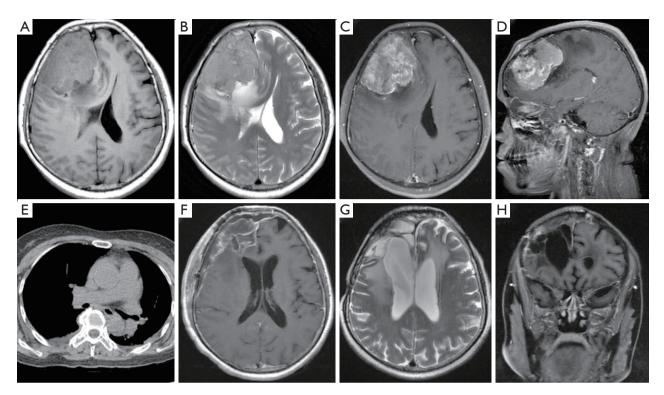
Preoperative and postoperative imaging data of patients. (A-D) MRI of the patient's brain before surgery in 2018, showing a large lobulated mass in the right frontal region (6.1 cm × 5.6 cm × 5.6 cm): (A) the T1-weighted image is mainly iso-intensity, and multiple spots and patchy low-intensity can be seen inside; (B) lesions that appeared iso- to hyper-intense on T2WI, multiple spots and flaky high signal can be seen inside. In addition, multiple vessels flow void sign can be seen around and inside the lesion; (C,D) transverse and sagittal T1-enhanced images, indicating that the mass has a rich blood supply, involves the adjacent frontal bone and grows extracranially, with cerebral herniation. (E) Preoperative chest CT plain scan showed no obvious abnormalities. (F) Postoperative transverse T1-enhanced image. (G,H) Brain MRI was re-examined 3 years after surgery (October 2021), and there was no clear sign of tumor recurrence. MRI, magnetic resonance imaging; T2WI, T2-weighted imaging; CT, computed tomography.
